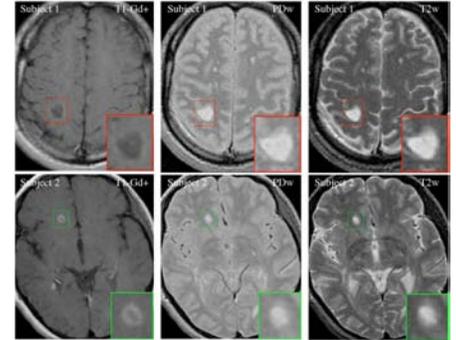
Example slices of 2 new lesions from 2 MS patients. Columns (left to right) show T1-Gd+, PD- and T2-weighted MRI. Evolution for these 2 lesions (PDw series) is shown in Fig.2
